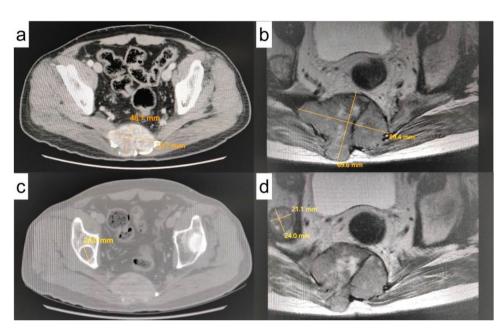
Comparative Post-Treatment Imaging of the sacral lesion and the right iliac lesion. a 21-month posttreatment of the sacral lesion on the pelvic CT. b 33-month post-treatment of the sacral lesion on the spinal MRI. c 21-month post-treatment of the right iliac lesion on the pelvic CT. d 33-month posttreatment of the right iliac lesion on the spinal MRI
